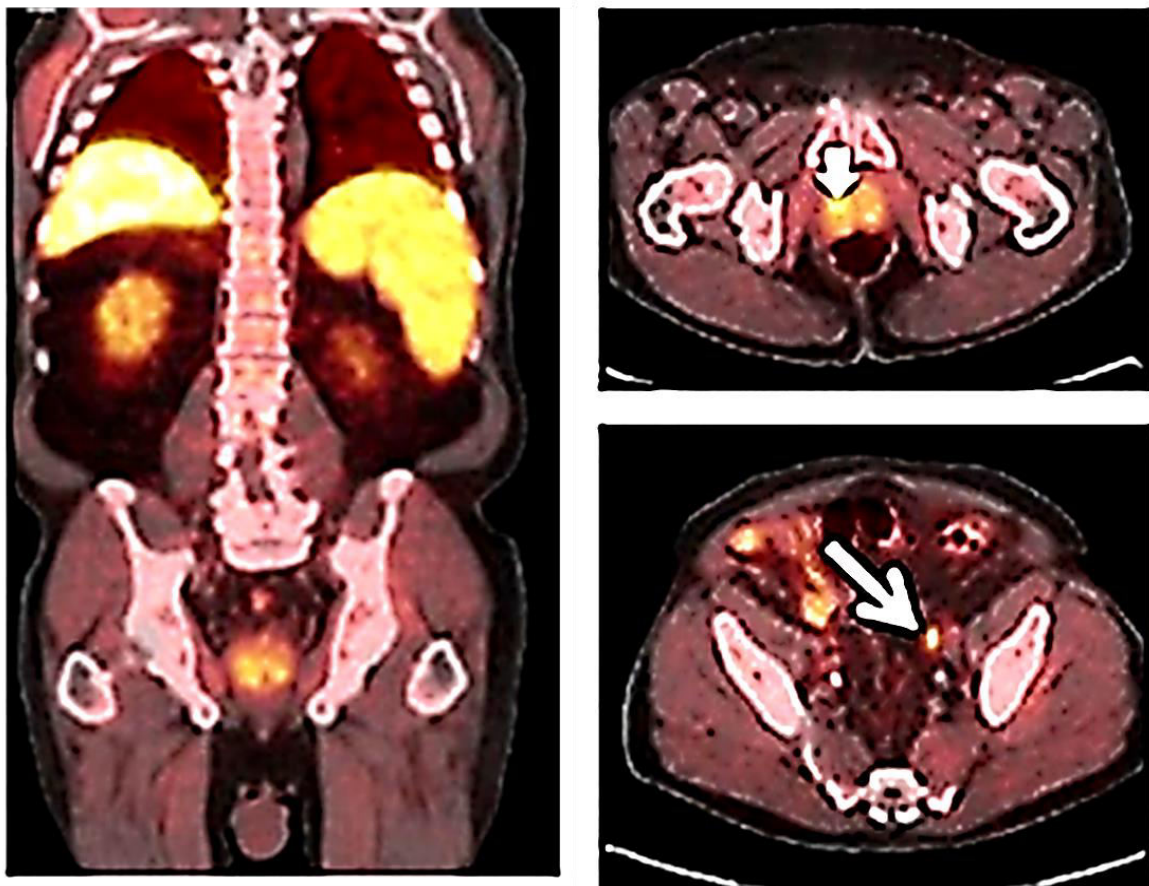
PET-CT images of a patient with prostate cancer, short arrow showed maximum standardized uptake value and long arrows indicate a normal-sized left external iliac lymph node
